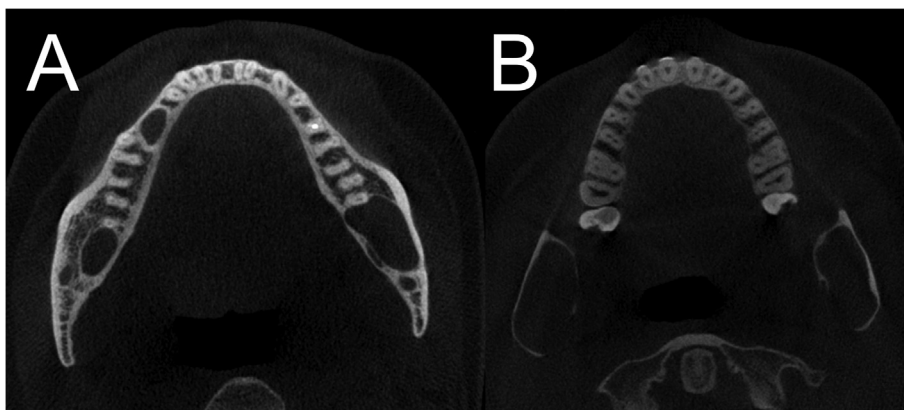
CBCT axial slices of a patient with NBCSS. Note the non-expansive lesions at the body of the mandible and bilateral expansive lesions at the left and right ascending ramus of the mandible.
